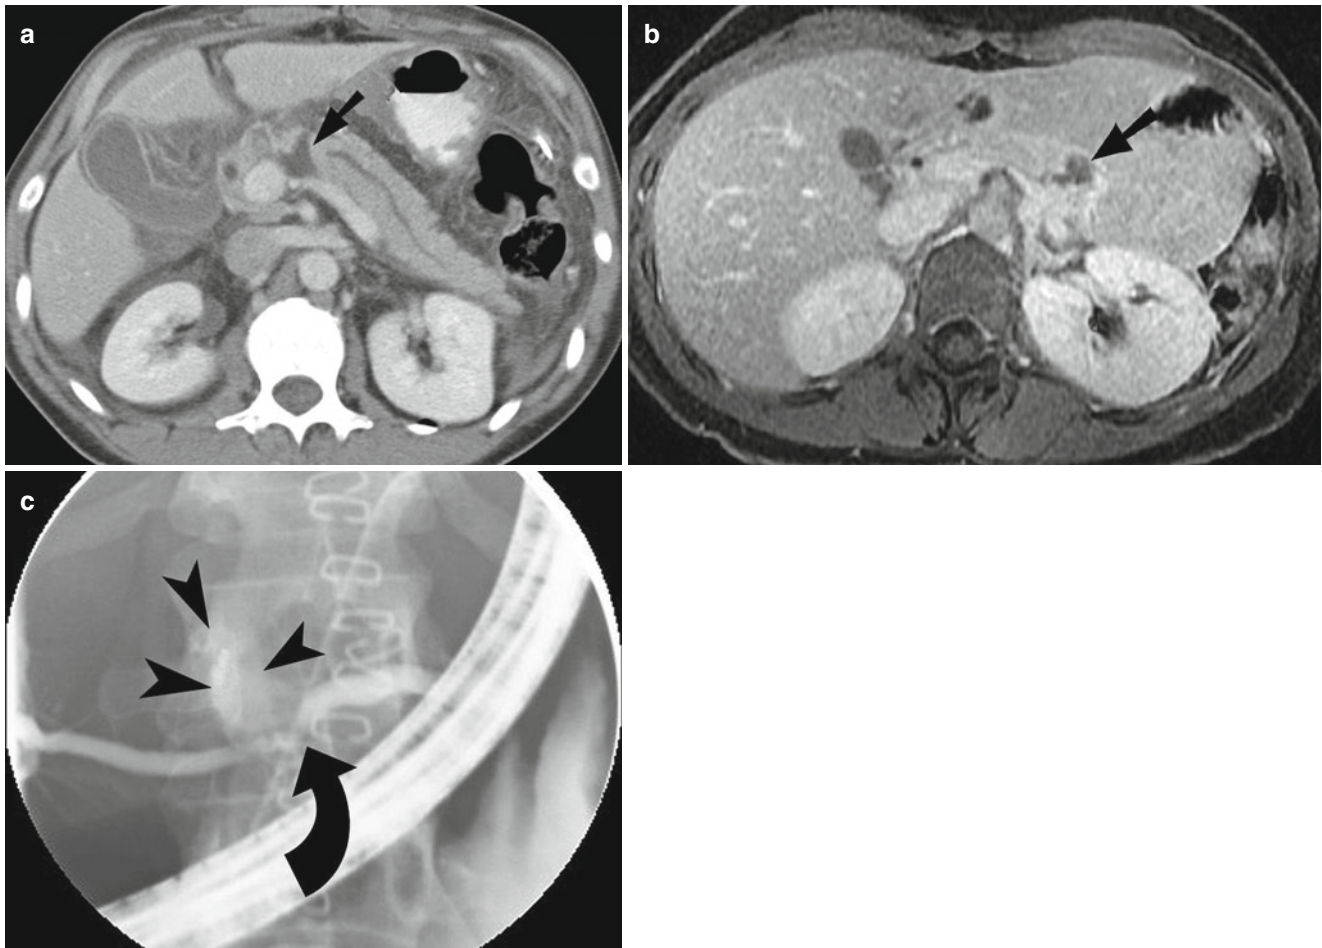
Pancreatic injury. (a and b) Contrast-enhanced CT demonstrates pancreatic laceration (*arrow*) with disruption of the main pancreatic duct. (c) Endoscopic retrograde cholangiopancreatography
